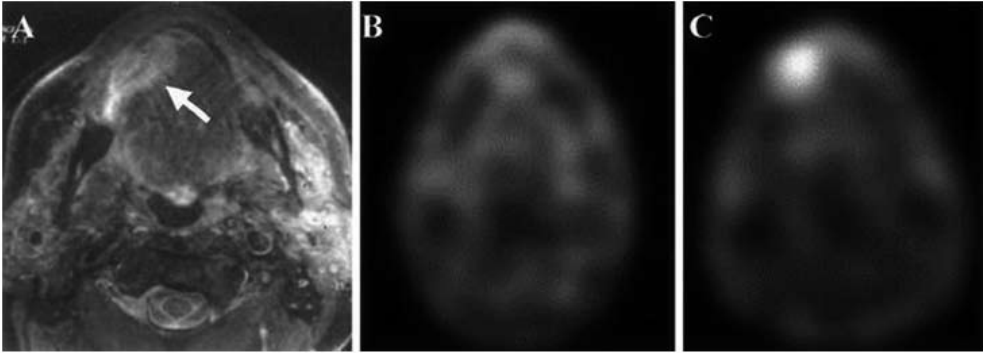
A Transaxial MRI showing a T2 tumor in the right side of the tongue (*arrow*). Tumor uptake of ^{99m}Tc -BRU 59-21, not observed on early transaxial SPET (B), is intense on late SPET (C).
